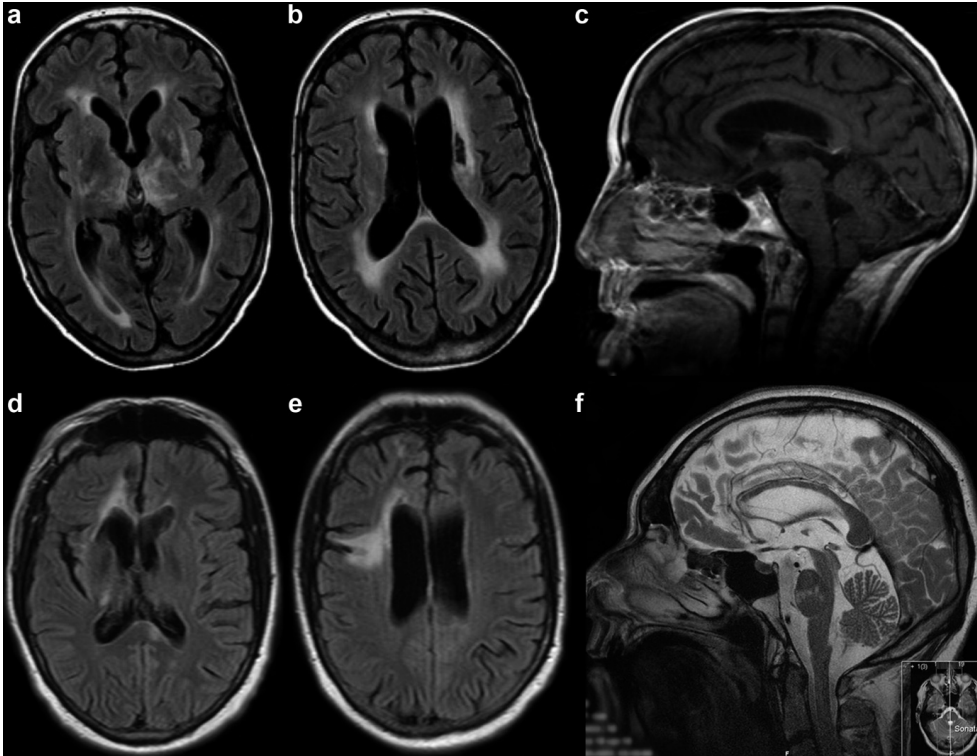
a–c Axial FLAIR MRIs and sagittal T1-weighted MRI of patient A at age 53 show signs of lacunar infarcts in the basal ganglia, bilateral periventricular white matter lesions, and a pontine infarct; d–f Axial FLAIR MRIs and sagittal T2-weighted MRI of patient B at age 47 show right frontal, basal ganglia, brainstem and corpus callosum infarcts.
